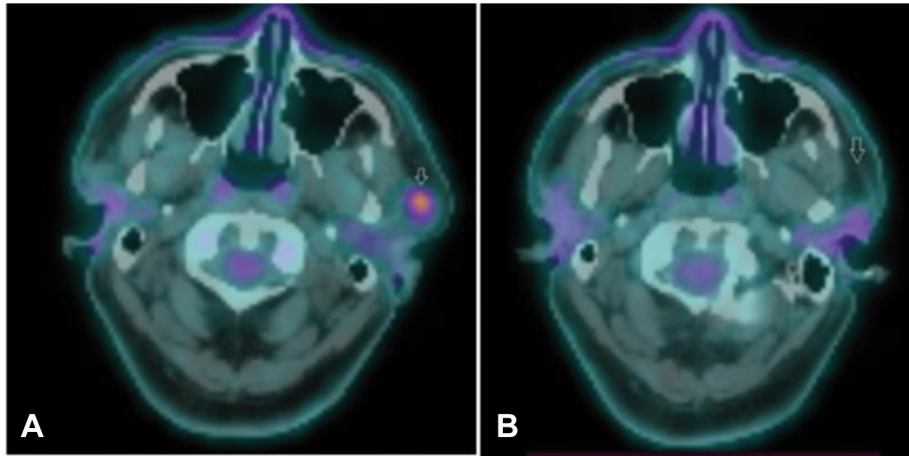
Left parotid lesion with significant radiopharmaceutical uptake on PET-CT performed before surgical intervention (A) and after parotidectomy (B).
